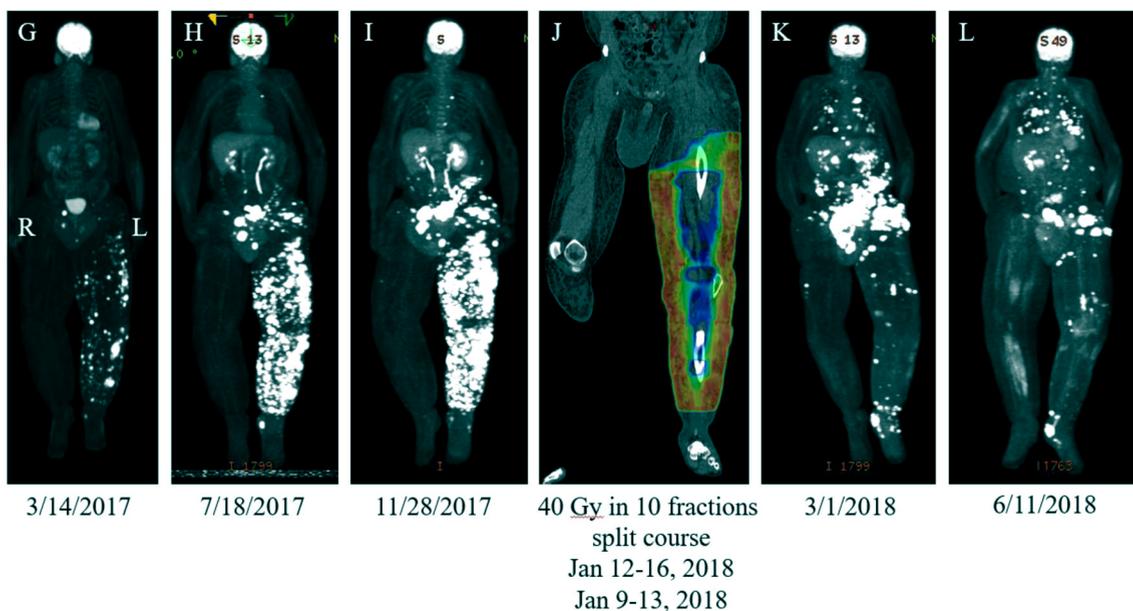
Staging positron emission tomography (PET), computed tomography (CT) scans, and radiation therapy (RT) planning for both cases.
